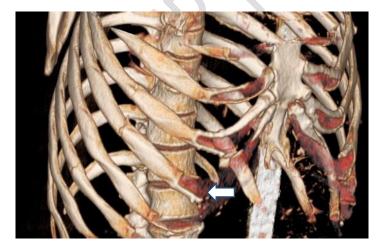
Thoracic CT scan with 3D reconstruction showing rib fractures (arrow)
